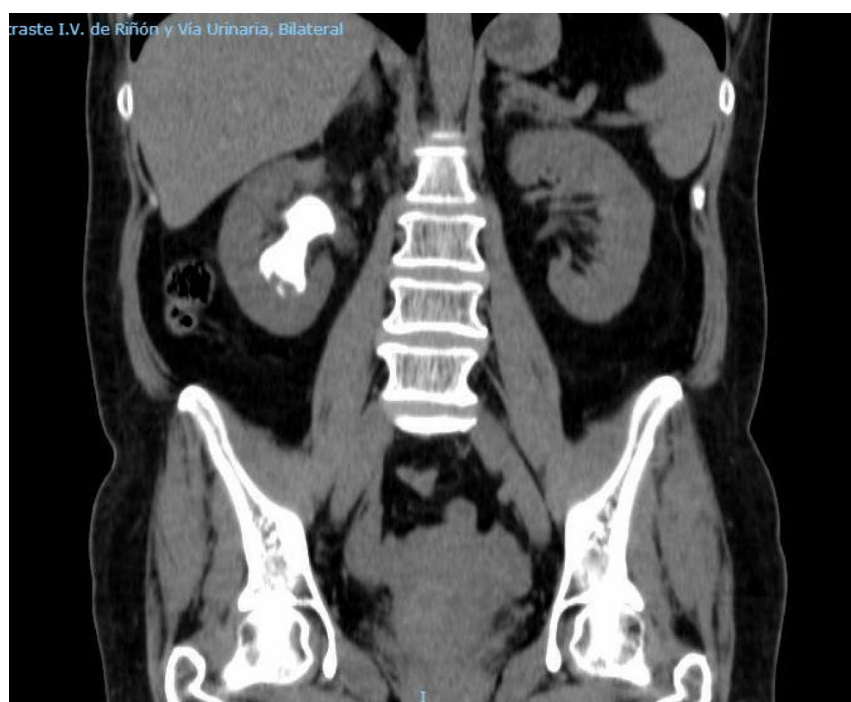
Coronal section in abdomino-pelvic CT scan
